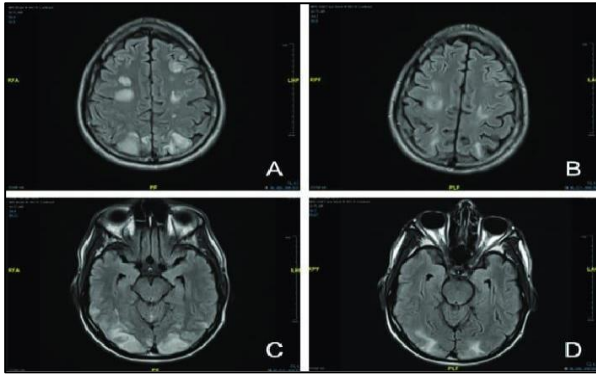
(A-D): MRI showing white matter hypodensities in parieto-occipital regions predominantly.
